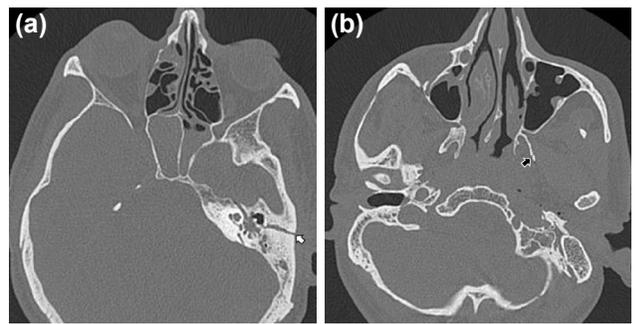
A 26-year-old man with temporal fracture. Axial computed tomography (CT) image (a) reveals an oblique fracture of the left temporal bone (arrow). The fracture extends through the left pterygoid plates (b, arrow).
